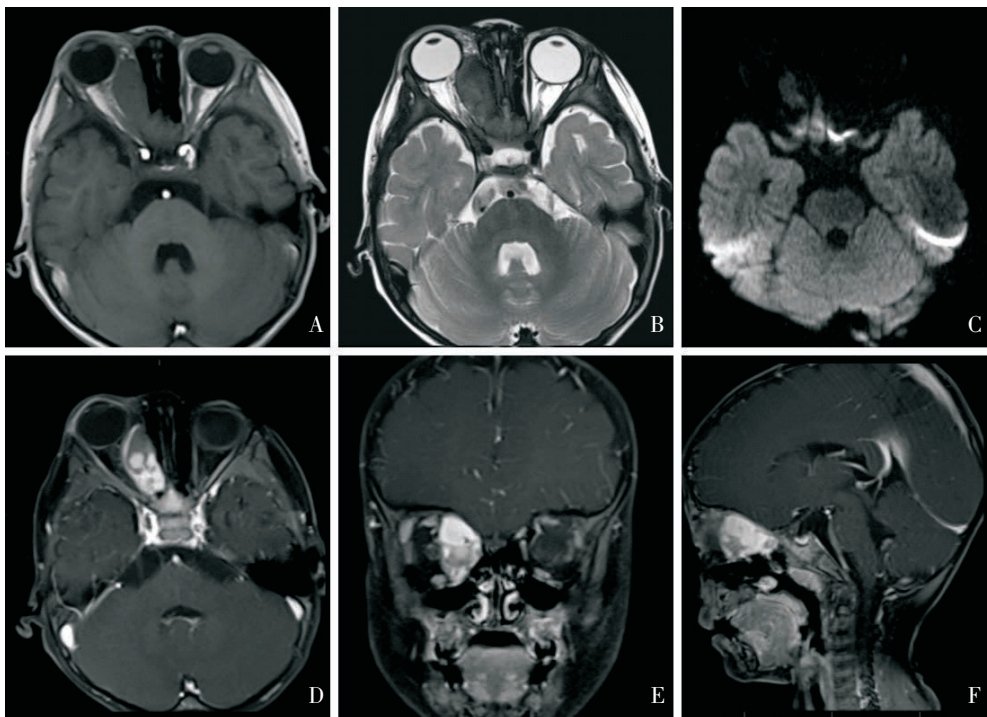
A 2-year-old boy with embryonal rhabdomyosarcoma. Figure 3A: Axial T1WI demonstrated an oval extraconal lesion in the right orbit with an isointense signal relative to the muscle. Figure 3B: The lesion showed a heterogeneously hyperintense signal on T2WI. Figure 3C: The lesion showed a hyperintense signal on DWI ($b=1000$). Figure 3D-F: The lesion showed a marked heterogeneous enhancement on postcontrast axial, coronal, and sagittal T1WI with fat saturation.
